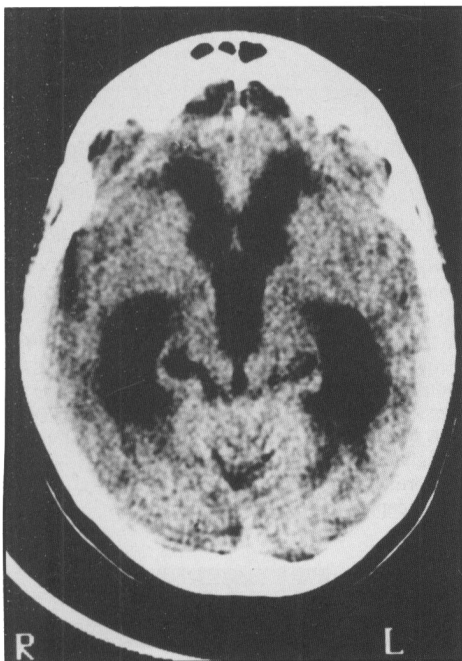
CT-scan showing marked hydrocephalus.
